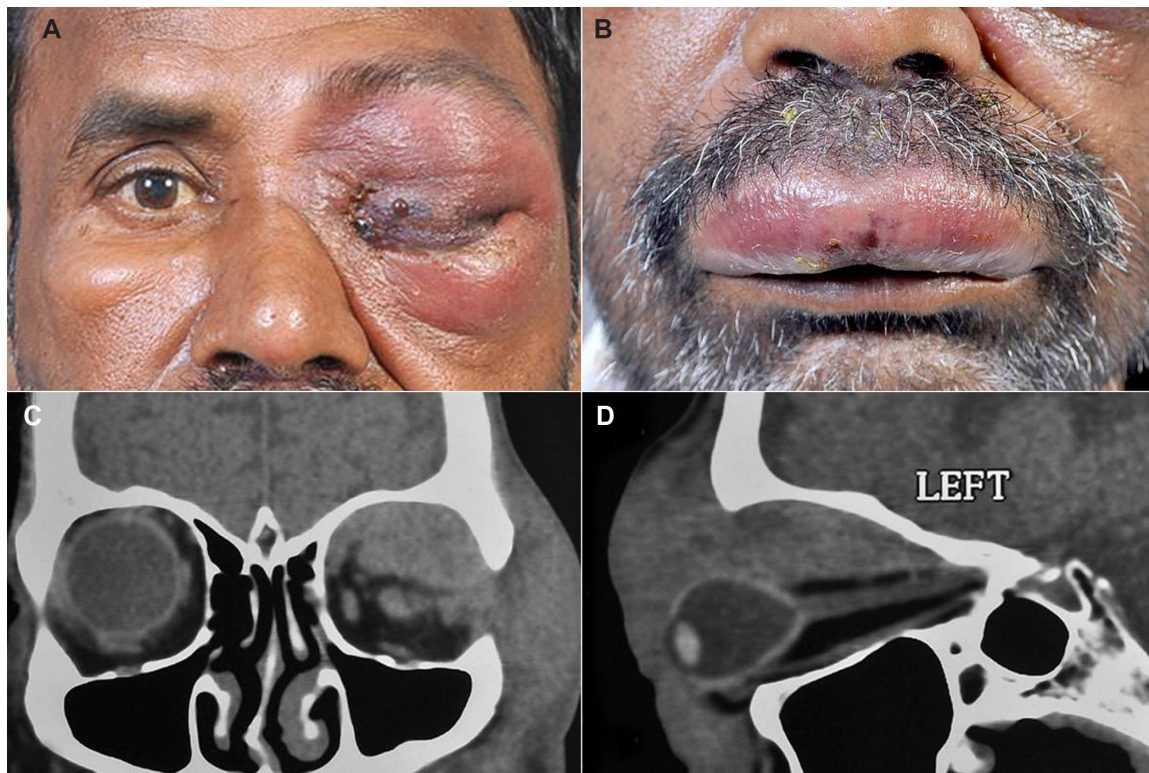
External photograph of the patient showing periorbital edema with total ptosis, skin induration, and blisters, as well as lip edema and blisters. External photograph of the patient showing left periorbital edema with total ptosis, skin induration, and blisters (A). External photograph showing upper lip edema with blisters (B). CT scan coronal cut of the same patient shows a diffuse ill-defined mass involving the entire superior orbit with superolateral bony erosion and extension into the temporal fossa (C). CT scan with sagittal reconstruction showing diffuse mass involving the entire superior quadrant up to the apex with indentation of the globe and optic nerve stretch (D). Abbreviation: CT, computerized tomography.
